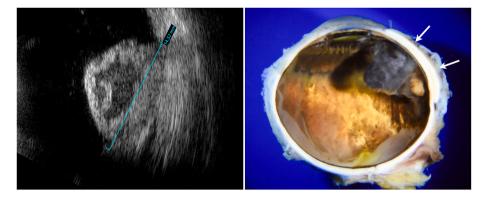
1A. B-scan ultrasonography discloses a dome-shaped mass with echolucency following plaque radiotherapy. 1B. Macrophoto of enucleated eye shows heavily pigmented mushroom-shaped ciliochoroidal tumor deep to scleral patch graft, which focally thickens the sclera (arrows).
